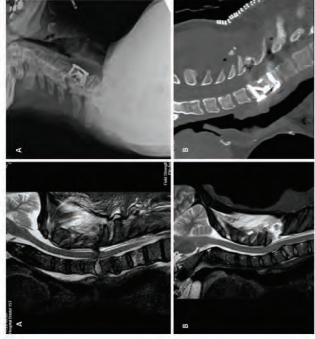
A) Pre-operative MRI of James G (left) followed by post-operative lateral view following the procedure (right). B) Post-operative MRI of James G (right) following the procedure (left) following the procedure (right).
